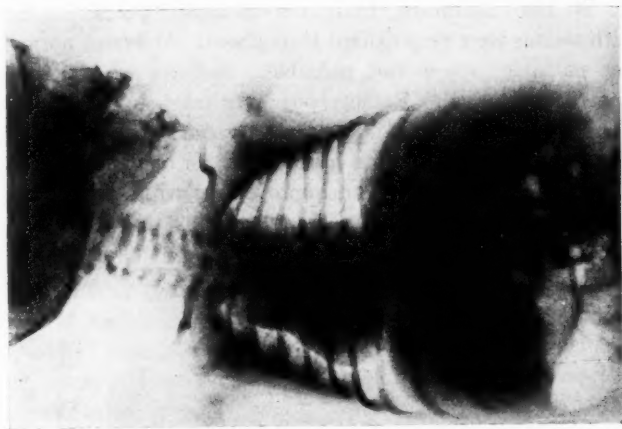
Case III. The same case after x-ray treatment.
